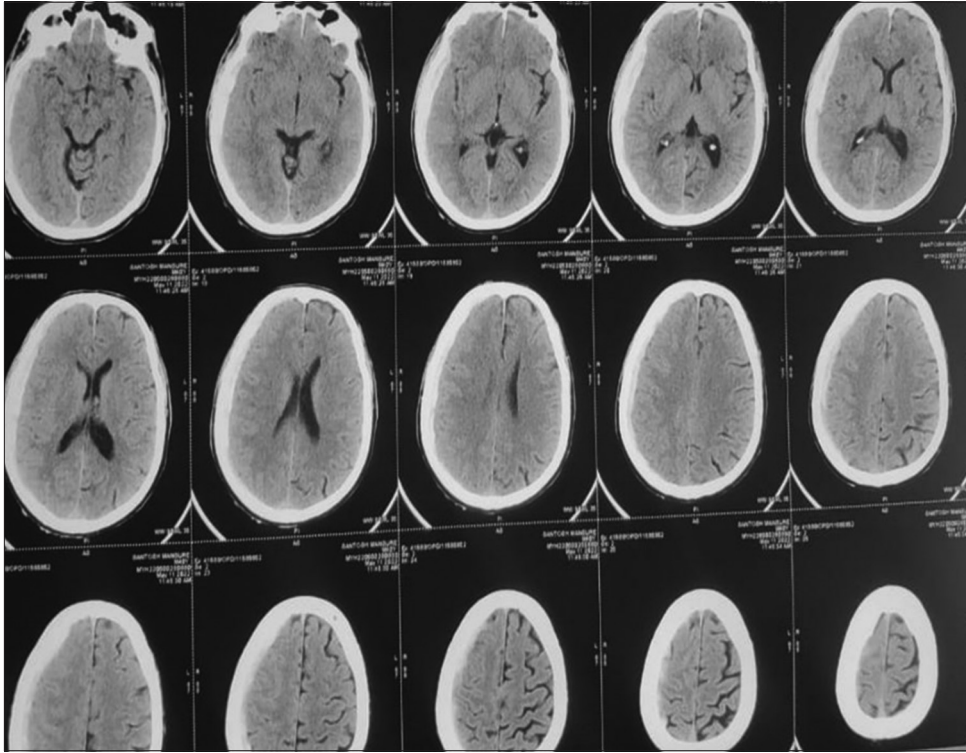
Initial non-contrast computed tomography with spontaneous right fronto-temporo-parietal subdural hematoma
